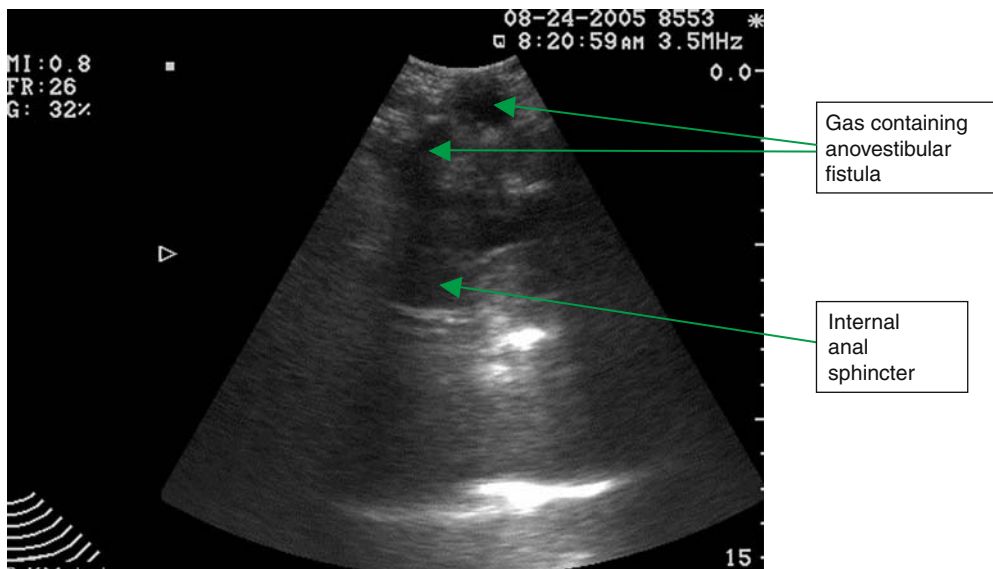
Axial transperineal ultrasonographic images of a 1-month-old baby girl presenting with a vestibular anus showing an intact internal anal sphincter over the covered anus with a gas-containing anovestibular fistula
